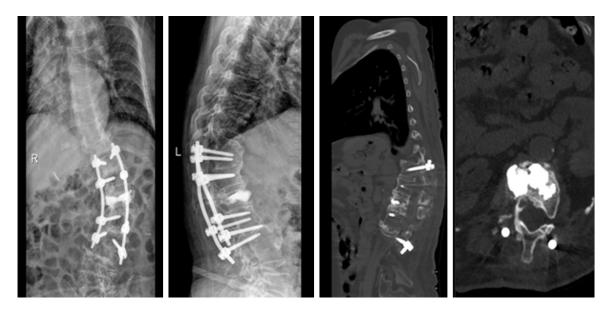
The postoperative X-ray and CT imaging examinations showing the appropriate internal fixation and eliminated bone nonunion filled by the bone cement.
